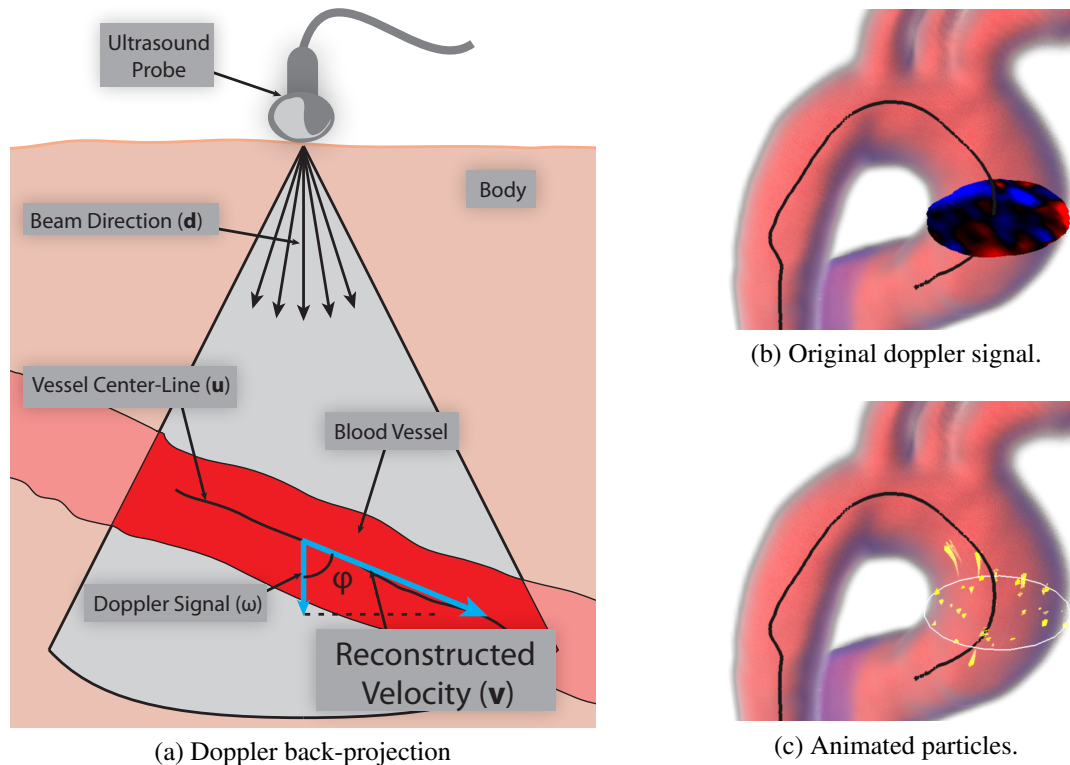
The velocity reconstruction is achieved by back-projecting the Doppler signal onto the vessel direction, as shown in (a). We can then translate the Doppler signal in (b) to the moving particles in (c)
